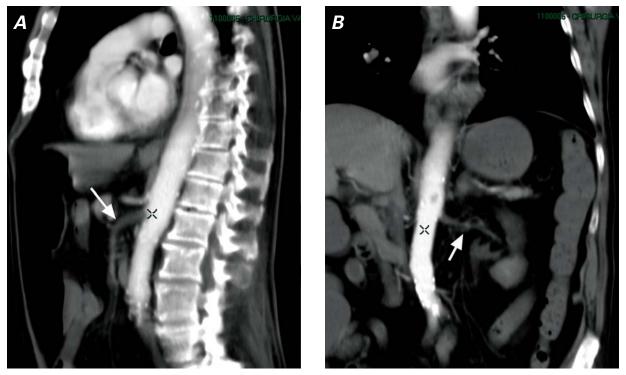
Computed tomograms with maximum intensity projection reconstruction show A) segmental obstruction of the superior mesenteric artery (arrow) in sagittal view, and B) obstruction of the left renal artery (arrow) in coronal view.
